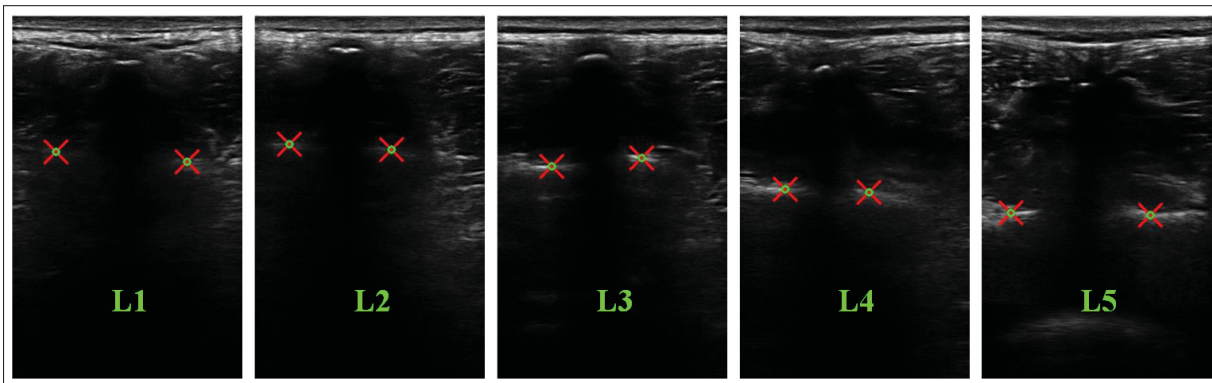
Raw ultrasound image samples of various lumbar vertebral levels from a participant with pairwise laminae landmarks labeled according to the protocol described in Section 2.3.1
